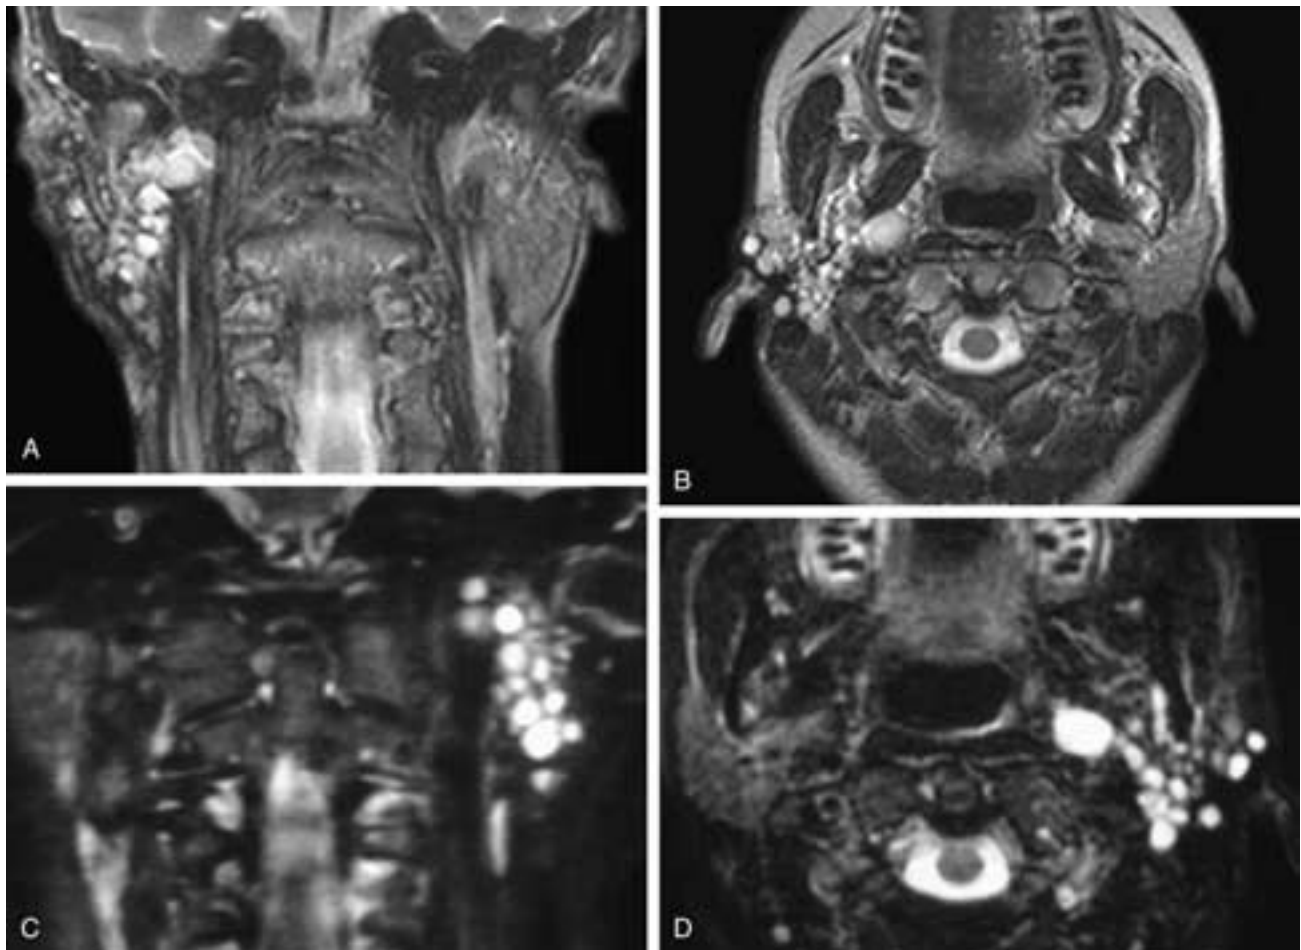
Coronal (A) and axial (B) T1-weighted, fat-suppressed, contrast-enhanced MR images show multiple discrete enhancing masses in the right parotid bed and parapharyngeal space. Coronal (C) and axial (D) T2-weighted images on another patient show multiple discrete high signal intensity masses within the left parotid bed and parapharyngeal space. Both of these patients had multiple recurrences of pleomorphic adenomas after parotidectomies.
